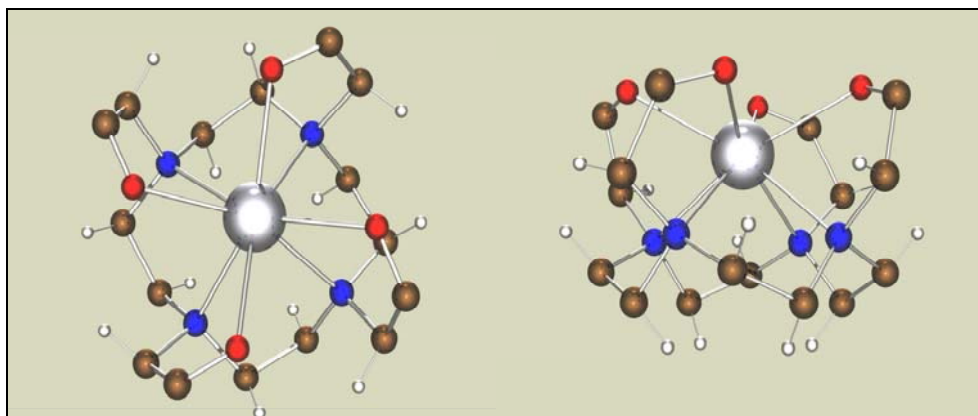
X-ray structure of Na[Bi(DOTA)](ball and stick representation) showing TSA (Δ - $\delta\delta\delta\delta$) arrangement
